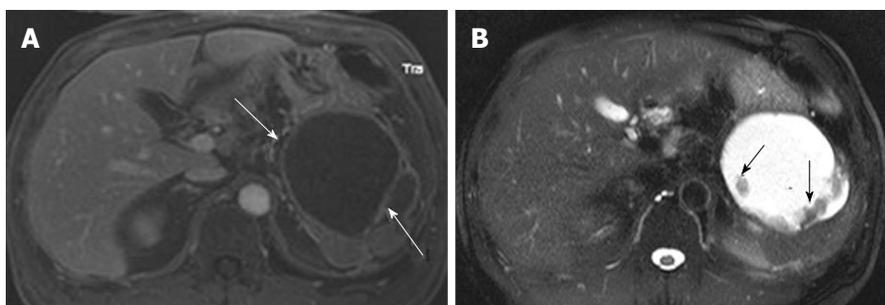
A 56-year-old male with chronic pancreatic pseudocyst. A: The venous phase of an axial contrast enhanced T1-weighted gradient-echo magnetic resonance image demonstrates a cystic lesion with thick cyst wall and septation (arrows) arising from the pancreatic tail. Although this is a male patient, making mucinous cystic neoplasm unlikely, imaging findings of chronic pseudocyst may still mimic mucinous cystic neoplasm; B: The axial fast spin-echo T2-weighted magnetic resonance image with fat saturation shows non-enhancing debris (A) attached to the cyst wall and the septum (arrows).
